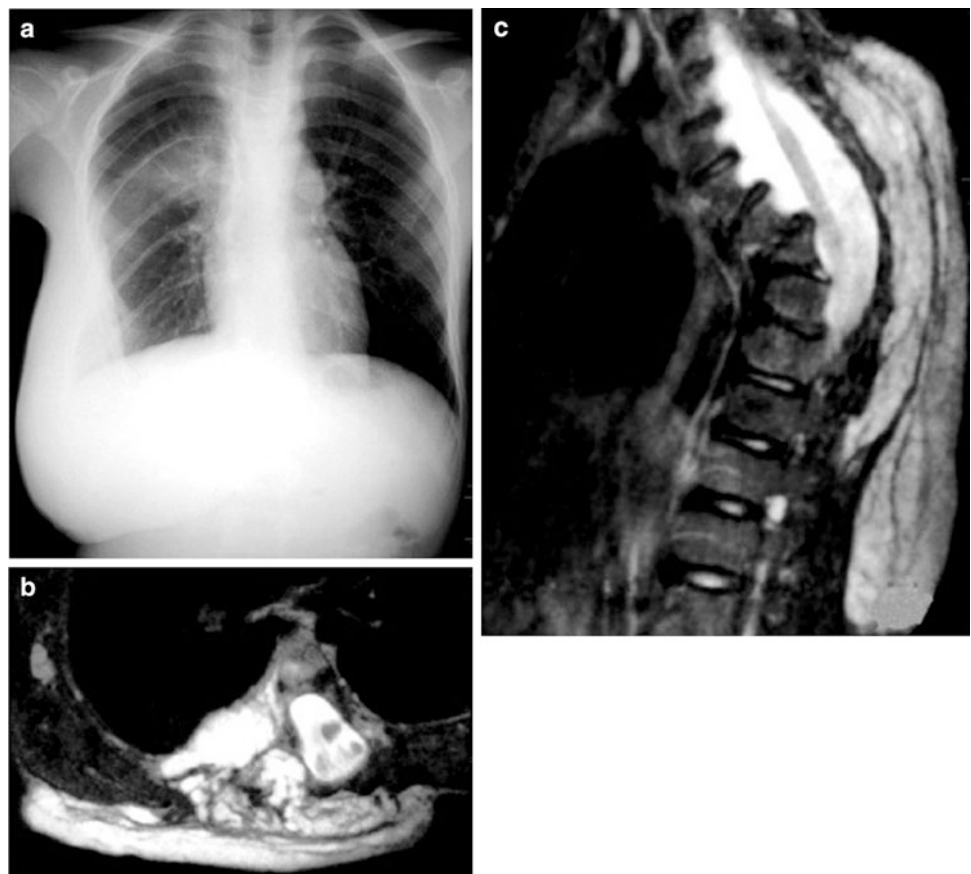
Congenital fibrosarcoma in a 3-day-old boy. a Chest X-ray shows large left extrathoracic soft tissue mass with severe displacement of ipsilateral scapula and deforming left hemithorax. b Coronal
